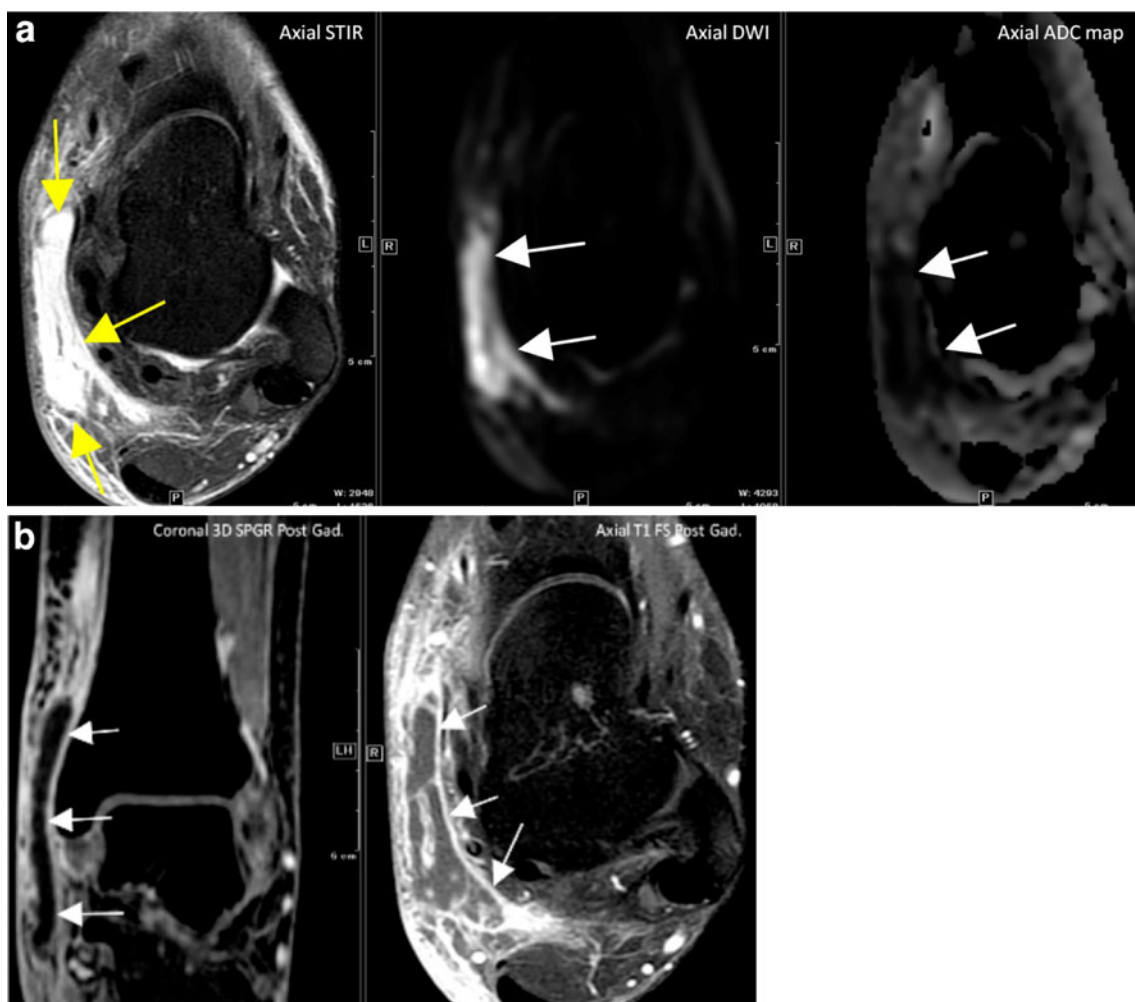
a (Case 4): Axial STIR MR image showing extensive subcutaneous edema along the medial aspect of the ankle along with tubular foci of brighter signal in keeping with focal fluid collection (*yellow arrows*). The fluid collection is DWI bright (*white arrows*) and ADC dark (*white arrows*) in keeping with avid restricted diffusion. b
